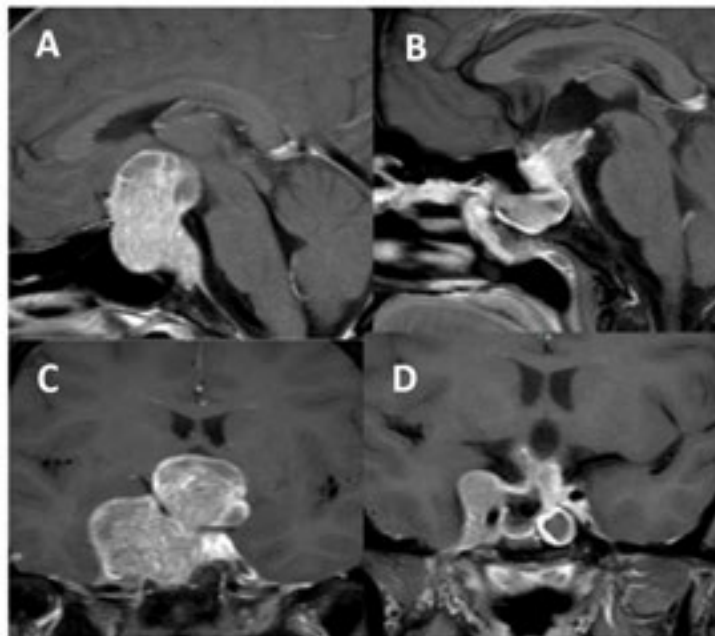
MRI showing partial resection of pituitary tumor.
